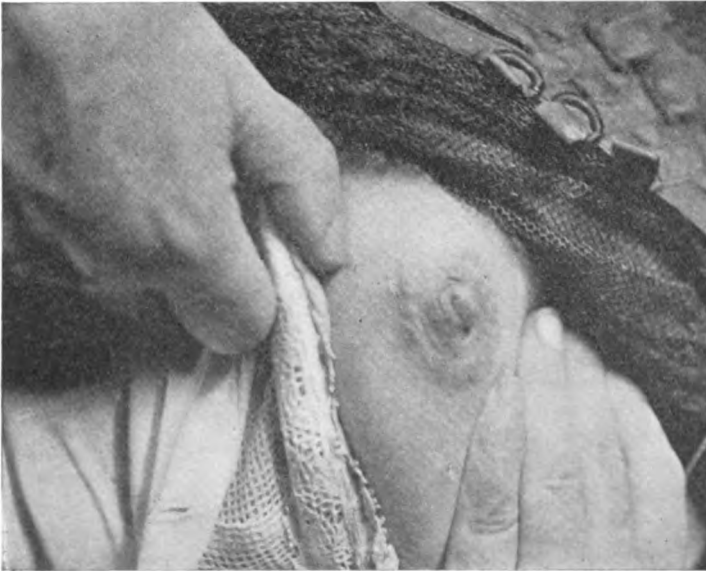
Epithelioma of nipple which had resisted radium treatment. Abandoned x-ray treatment after three applications.
